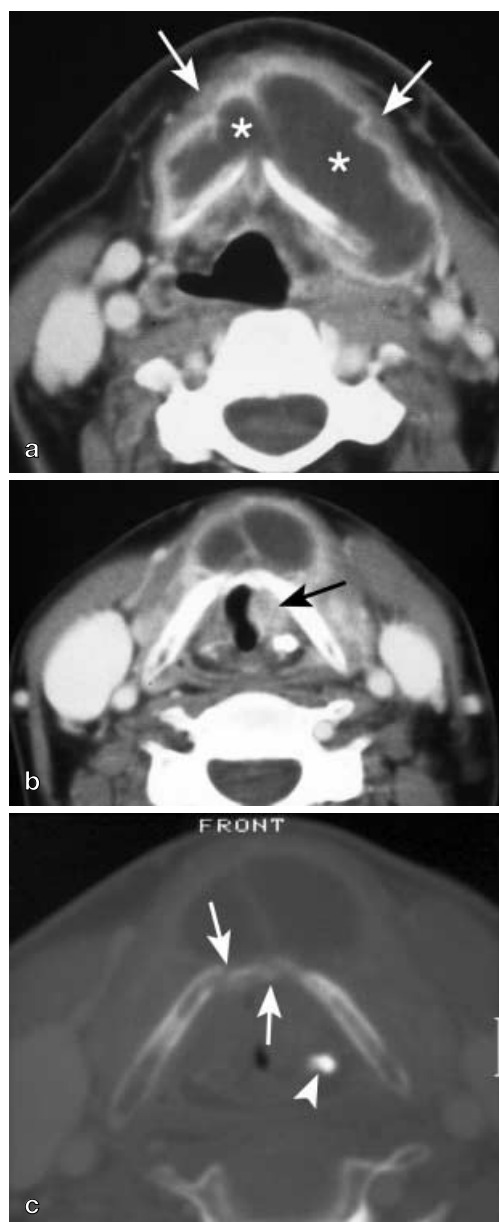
Axial contrast-enhanced CT images. a Supraglottic level. Large fluid collection (asterisks) with rim enhancement is seen in the prelaryngeal soft tissues, displacing the strap muscles (arrows) anteriorly. b Glottic level. The large fluid collection extends downwards to this level. Thickening and enhancement of the left true vocal cord (arrow). c Same level as b, bone window. Fragmentation of the anterior part of the thyroid cartilage (arrows). Sclerosis of left arytenoid cartilage (arrowhead)
